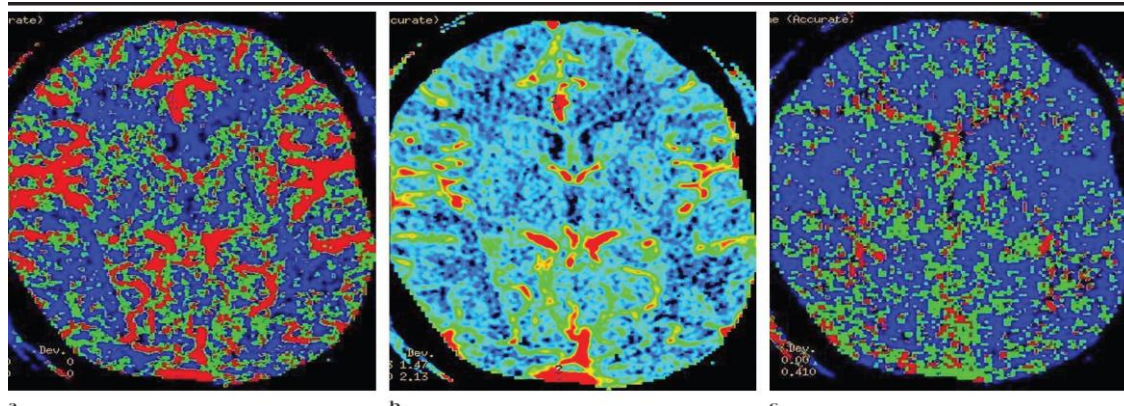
Perfusion maps (transverse CT) in a healthy adult volunteer show normal perfusion. Various colour ramps, selected according to user preference, are used to display the (a) CBF, (b) CBV, and (c) MTT maps
